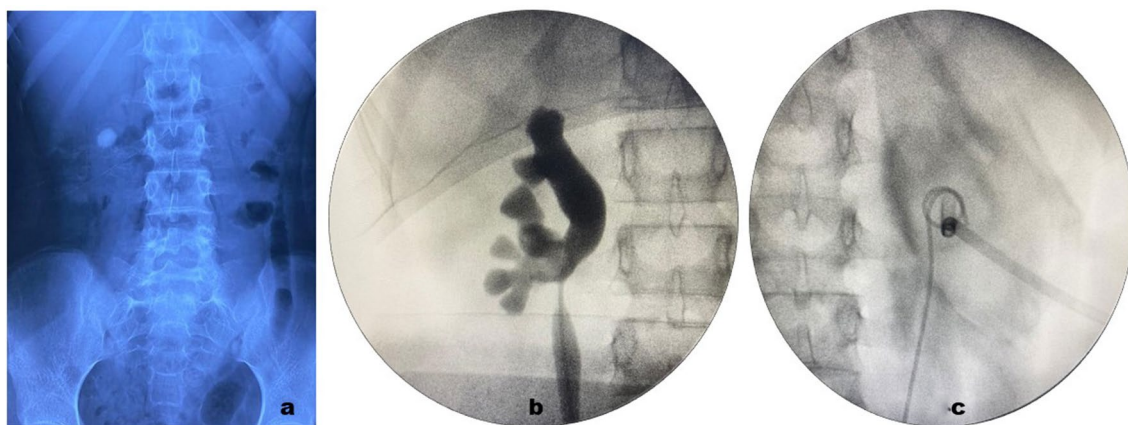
a Plain X-ray KUB shows a 13 mm calculus in the Rt. kidney in a 15 yrs. old girl. b Shows pre-PCNL Rt. retrograde pyelography. c Shows complete clearance of stone following PCNL
